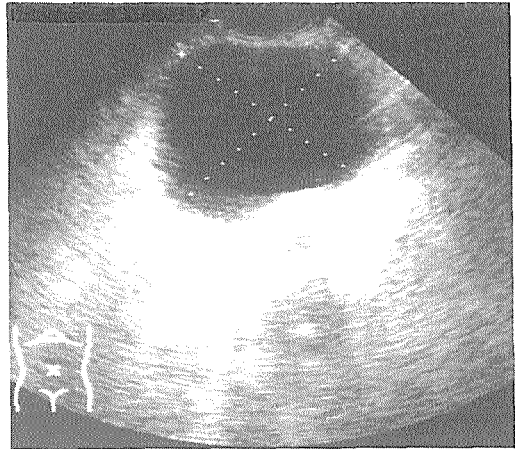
Ultrasonogram (US) of fluid collection in bursa omentalis.
